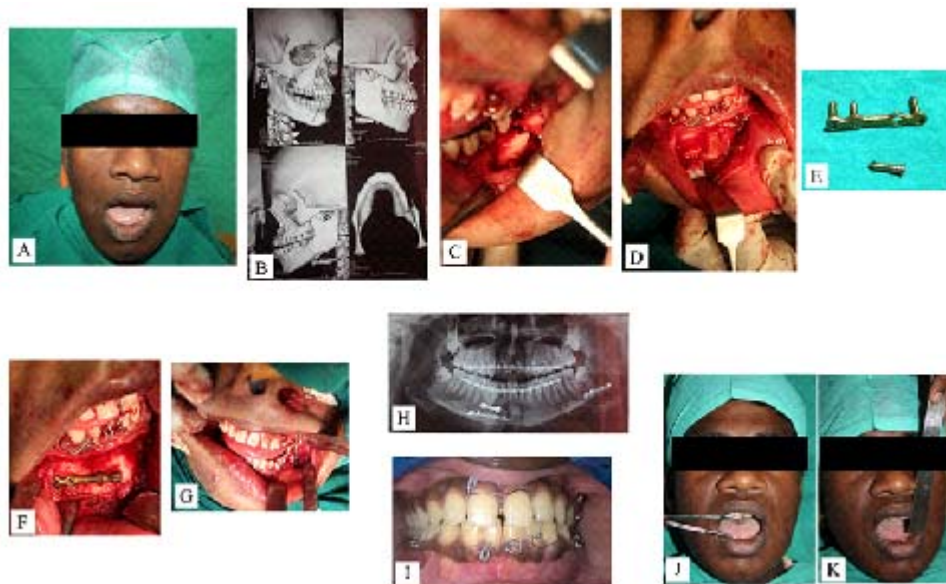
A. Pre operative photograph; B. Pre operative CT scan; C & D. Fracture site is exposed in angle region & parasymphysis region, E. 2mm Locking miniplates and screws; F&G. Plating done with 2mm locking plate & screws; H. Post operative OPG; I. Post operative Occlusion, J & K. Post operative mouth opening
